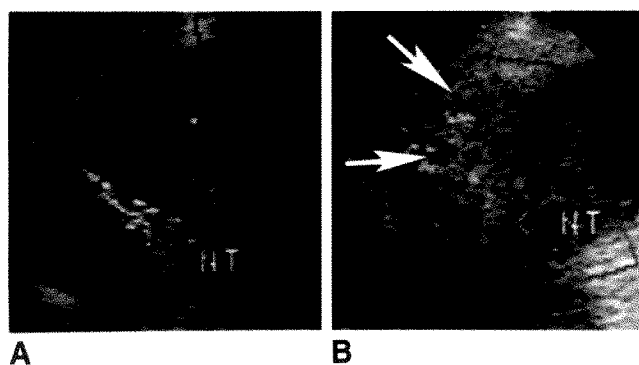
A, Color Doppler sonogram of aspiration of liver mass (hepatocellular carcinoma). 20-gauge needle and tip (NT) outlined by color image produced by gentle motion of needle.
